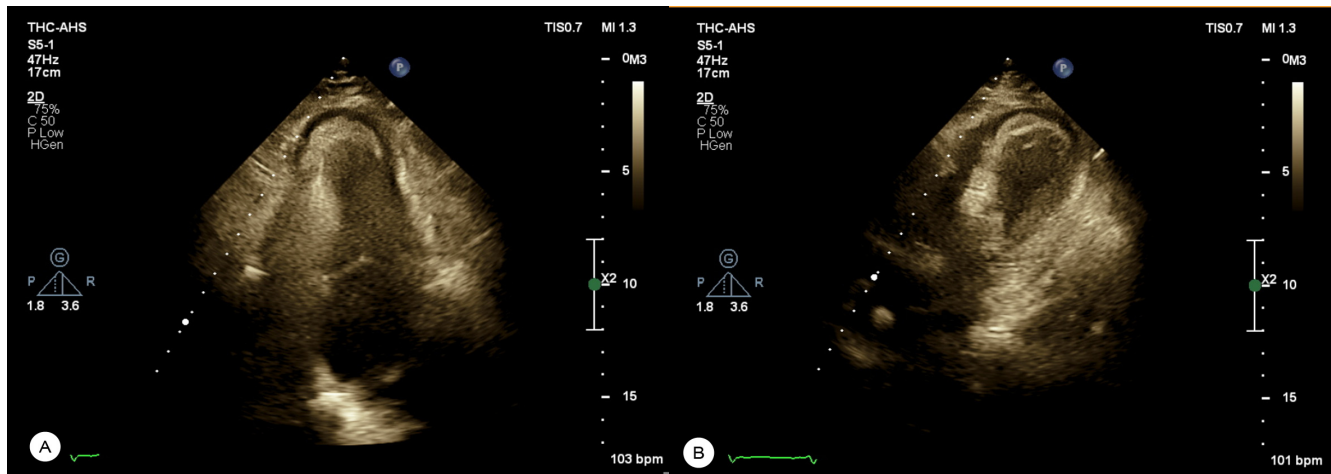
The patient's trans-thoracic echocardiographic examination in the apical 4-chamber view shows left ventricular apical thinning and aneurysmal formation with a hyperechoic mass, raising suspicion of thrombosis.
